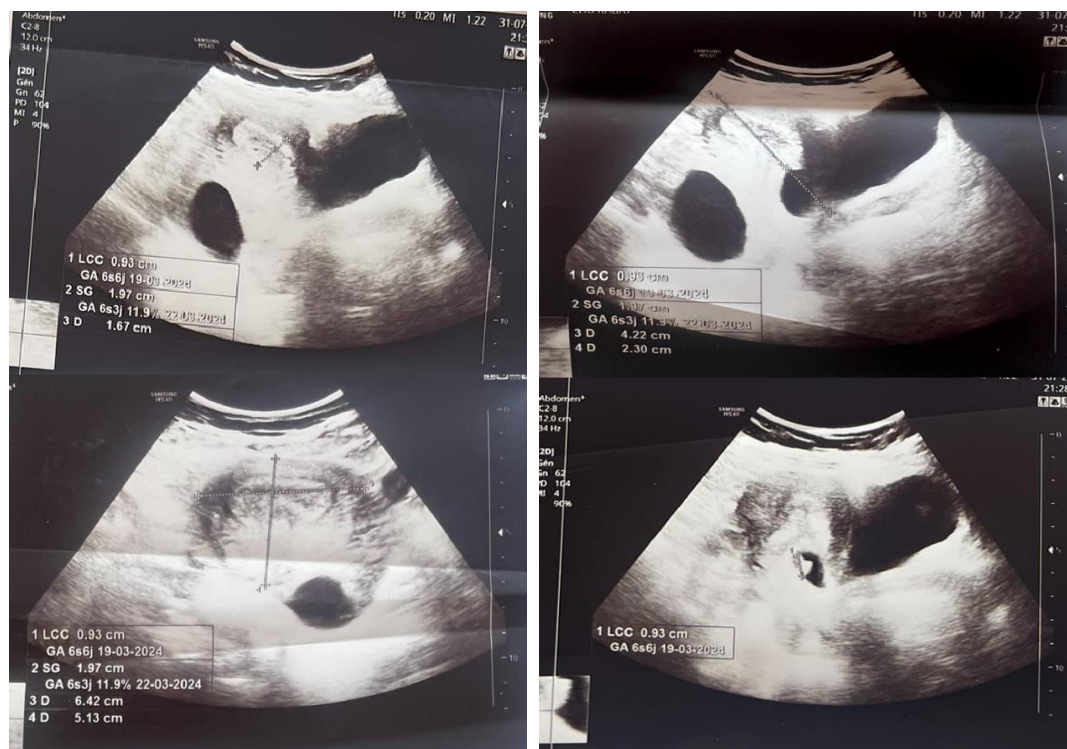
Ultrasound images of the c-section scar ectopic pregnancy.
